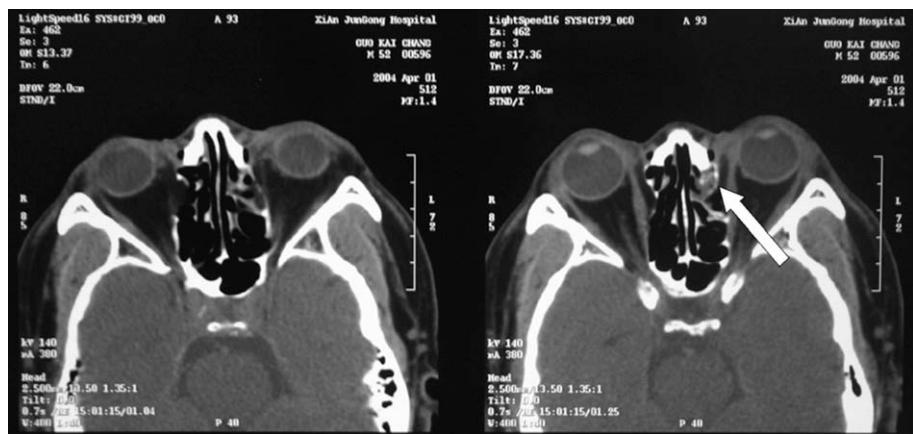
CT direct sign: left eye, bone substance continuity of orbital medial wall broke off, and also orbital wall displaced; indirect sign: hematocele on the site of fracture (see white arrow).
